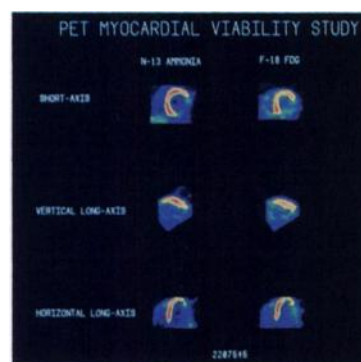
"Matched" areas of reduced resting perfusion and FDG retention as seen in the posterolateral wall of this patient with previous inferior myocardial infarction represent scar or non-viable myocardium.
